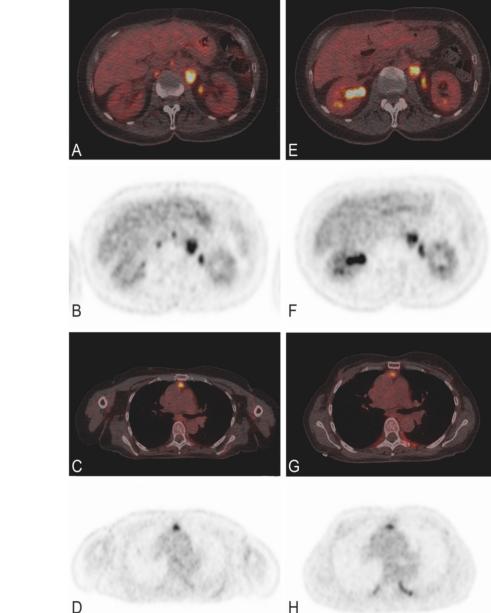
Response monitoring lymph node and pulmonary metastases. PET/CT (A, C, E, G) and PET (B, D, F, H) images before (A-D) and after (E-H) three cycles of capecitabine.
